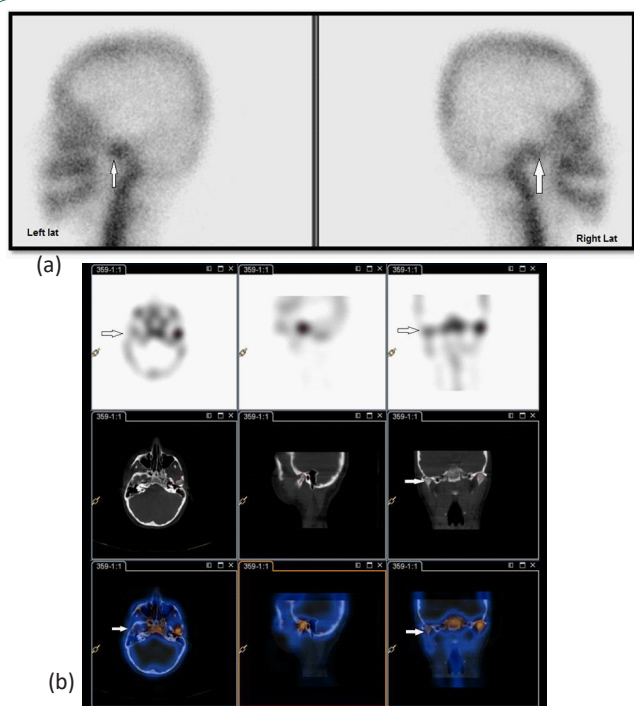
Planar (a) and SPECT CT (b) bone scan images showed hypoplastic right mandibular condyle with decreased radiotracer counts (underactive) compared to the left side (Arrows).
